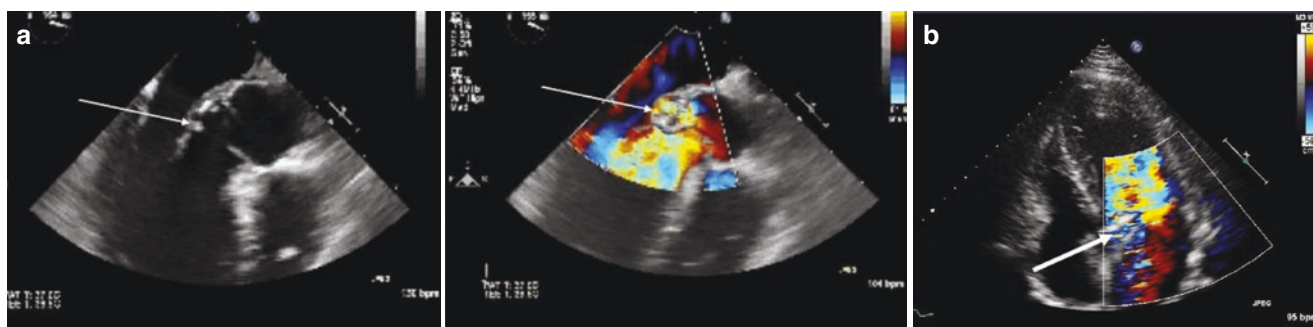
(a) Aortic root abscess (arrow) seen by TEE with color flow Doppler and severe aortic regurgitation in a patient with infective endocarditis. (b) In this patient with aortic endocarditis, a fistula (arrow) has formed between the aortic root and the left ventricle
